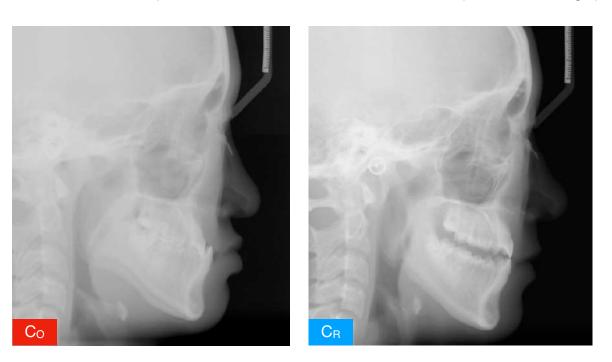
Cephalometric radiograph in the C_0 (left) and C_R (right) positions. See text for details.
